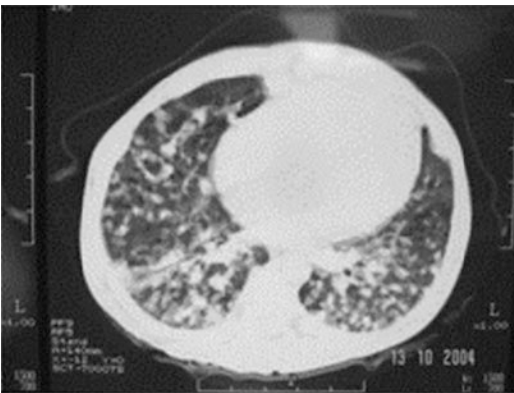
CT scan in congenital TB with multiple low attenuation areas
